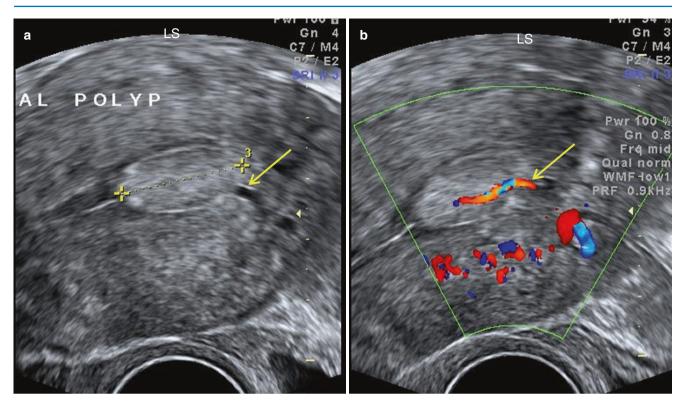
Hyperechoic polyp clearly visualised in a proliferative endometrium. The hyperechoic line surrounding the polyp is discontinuous at the site of entry of the feeder vessel (*arrow*) which is seen on (a) greyscale and (b) Doppler
